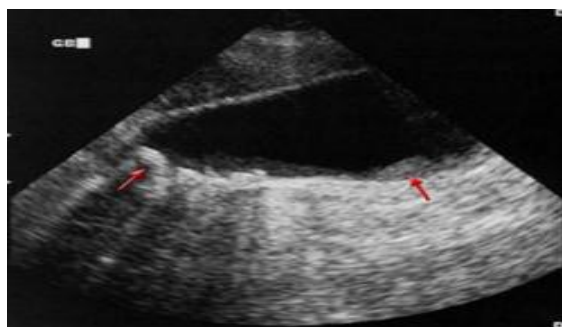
Sagittal sonogram in a 71-year-old woman. This image demonstrates heterogeneous thickening of the gallbladder wall (arrows). The diagnosis was primary papillary adenocarcinoma of the gallbladder
